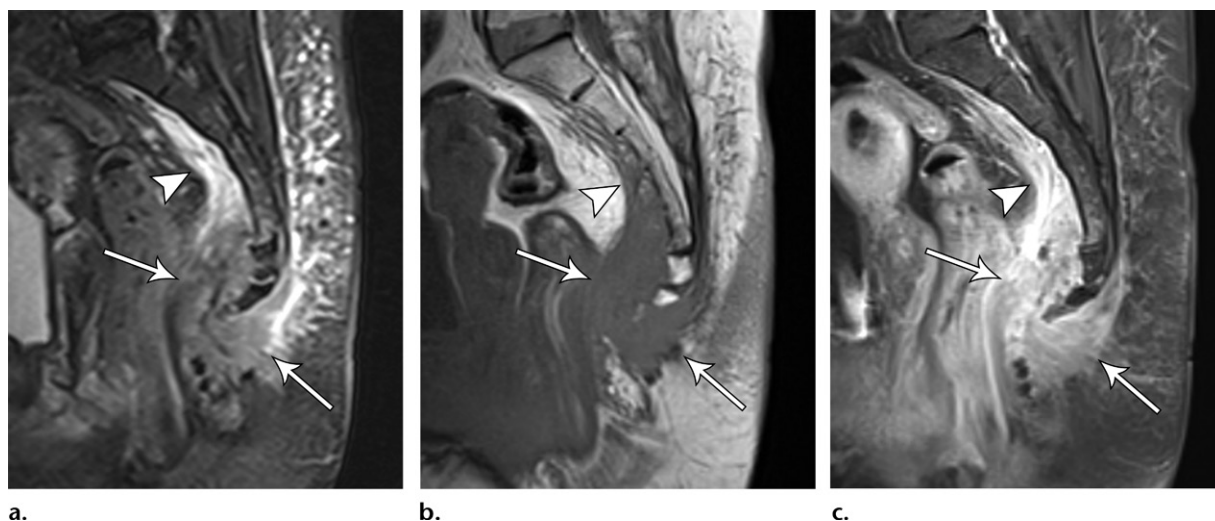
Paraganglioma in a 68-year-old woman with 2 years of worsening sacrococcygeal pain. Sagittal STIR (a), T1-weighted (b), and contrast-enhanced T1-weighted fat-suppressed (c) images show an enhancing mass lesion surrounding the coccyx (arrows), extending cephalad into the presacral fat (arrowhead). This proved to be a paraganglioma.
